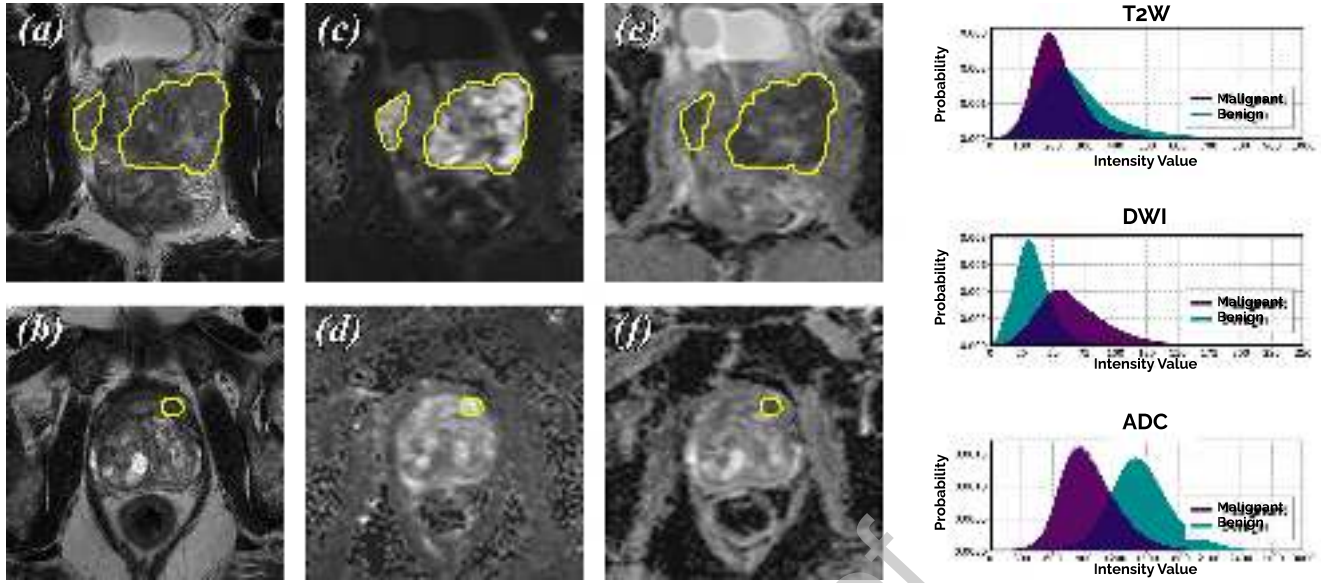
The challenge of discriminating csPCA due to its morphological heterogeneity. (a-b) T2-weighted imaging (T2W), (c-d) diffusion-weighted imaging (DWI) and (e-f) apparent diffusion coefficient (ADC) maps constituting the prostate bpMRI scans for two different patients are shown above, where yellow contours indicate csPCA lesions. While one of the patients had large, severe csPCA developing from both ends (*top row*), the other was afflicted by a single, relatively focal csPCA lesion surrounded by perceptually similar nodules of benign prostatic hyperplasia (BPH) (*bottom row*). Furthermore, probability density functions (*right*) compiled from all 2732 scans used in this study, revealed a large overlap between the distributions of csPCA and non-malignant prostatic tissue across all three MRI channels.
